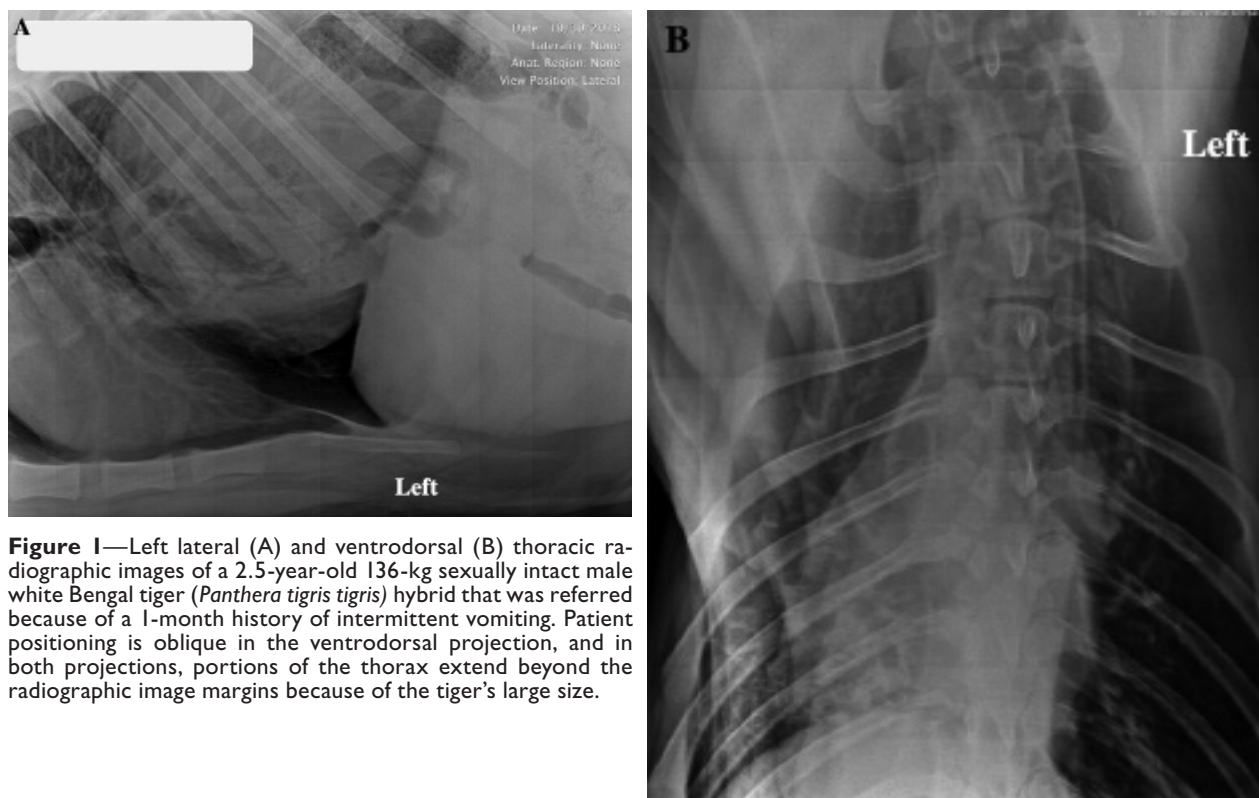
Left lateral (A) and ventrodorsal (B) thoracic radiographic images of a 2.5-year-old 136-kg sexually intact male white Bengal tiger (*Panthera tigris tigris*) hybrid that was referred because of a 1-month history of intermittent vomiting. Patient positioning is oblique in the ventrodorsal projection, and in both projections, portions of the thorax extend beyond the radiographic image margins because of the tiger's large size.
